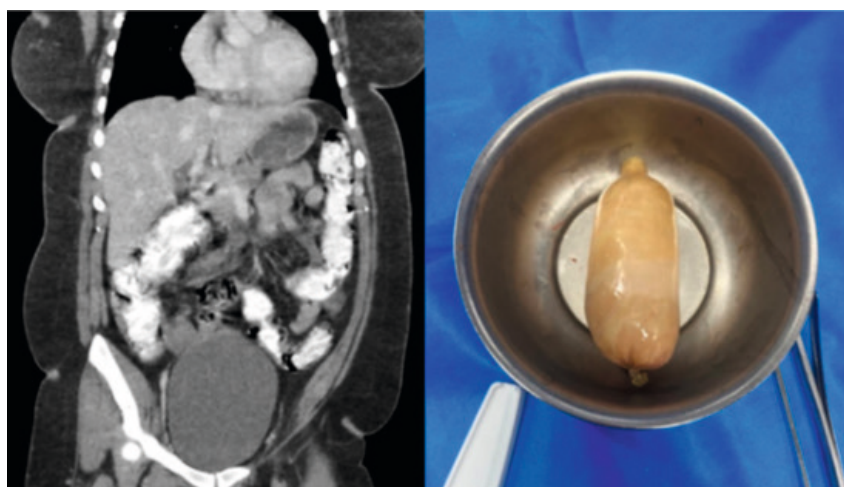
Left: Coronal reconstruction of an abdominal-pelvic CT scan with contrast, showing high-density material along the colonic trunk. Right: One of the packets of liquid cocaine removed during surgery.
